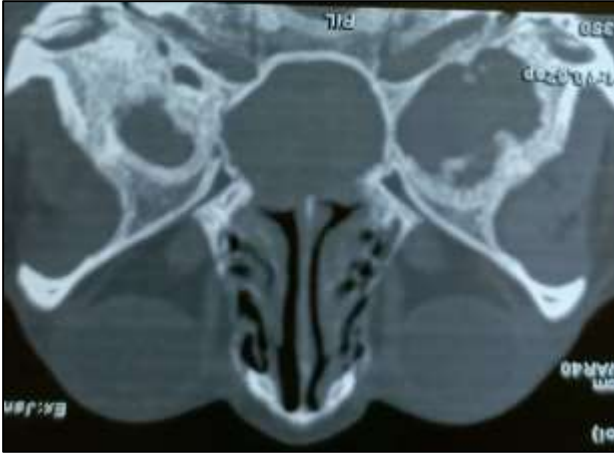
CT scan of nose and paranasal sinus (axial view) is showing sphenoid sinus mucocele.
